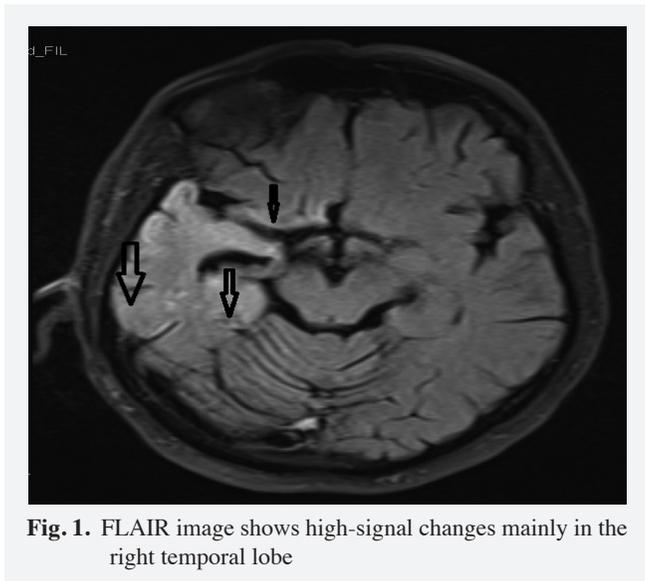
FLAIR image shows high-signal changes mainly in the right temporal lobe
